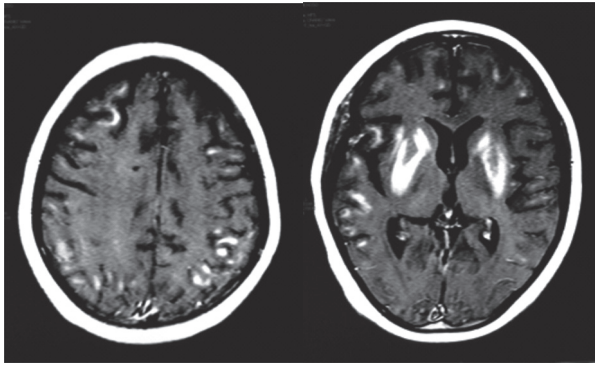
Axial MRI in T1 with contrast. Uptake in the bilateral lentiform nuclei and diffusely in the subcortical white matter
